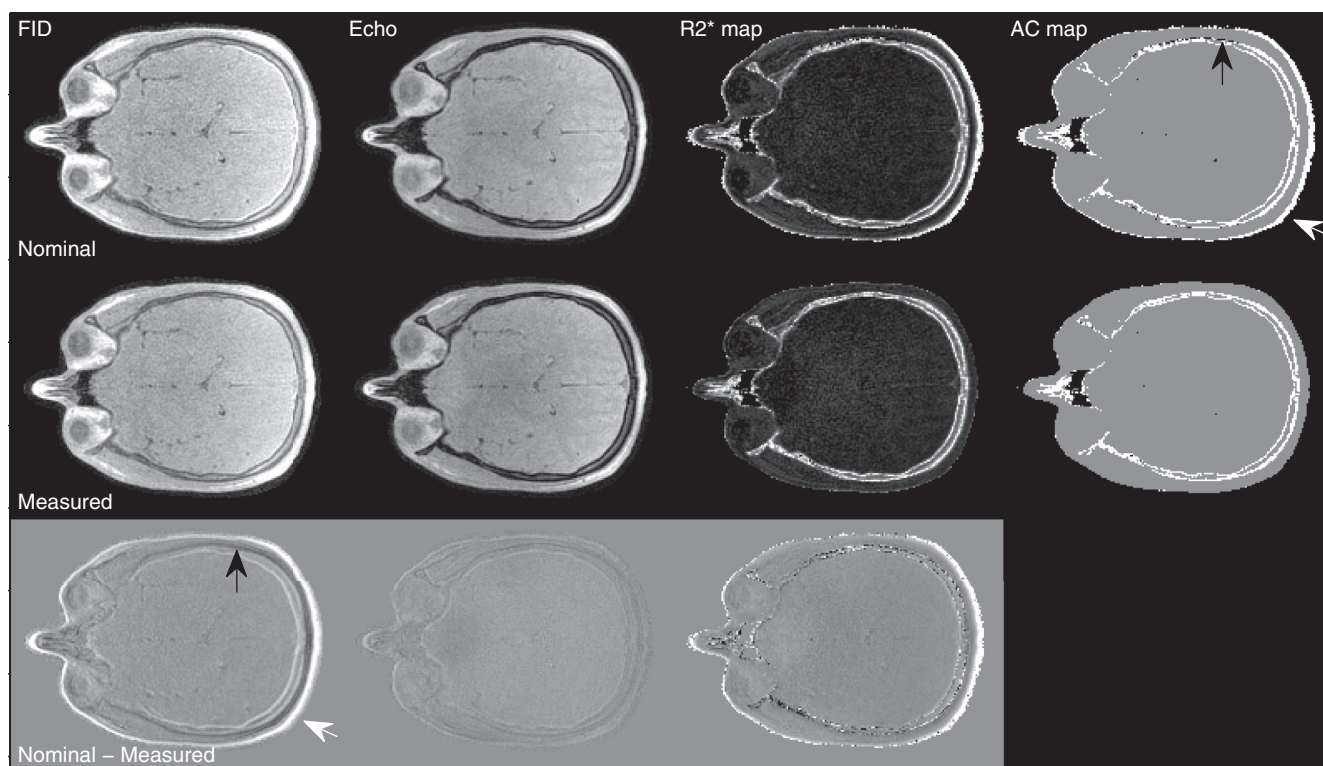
UTE-MR images of the head of a volunteer. Top row: FID and echo images reconstructed with nominal k-space trajectories and corresponding  $R_2^*$  and segmented attenuation map. Middle row: As top row but with reconstruction performed with k-space trajectories measured with a field camera. Bottom row: Differences between images reconstructed with nominal trajectories and with measured trajectories. Black arrows show hypointense artifacts on the bone–soft tissue border, leading to misclassification of bone as air. White arrows show hyperintense artifacts on the air–soft tissue border, leading to misclassification of soft tissue as bone.
